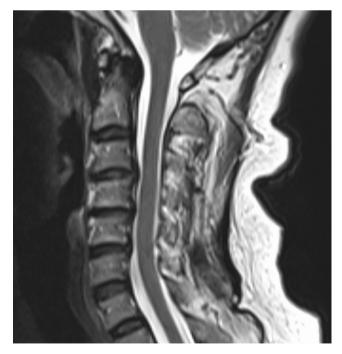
Sagittal T2-weighted cervical magnetic resonance imaging on the second day after onset indicating that the hematoma is observed to have disappeared.
